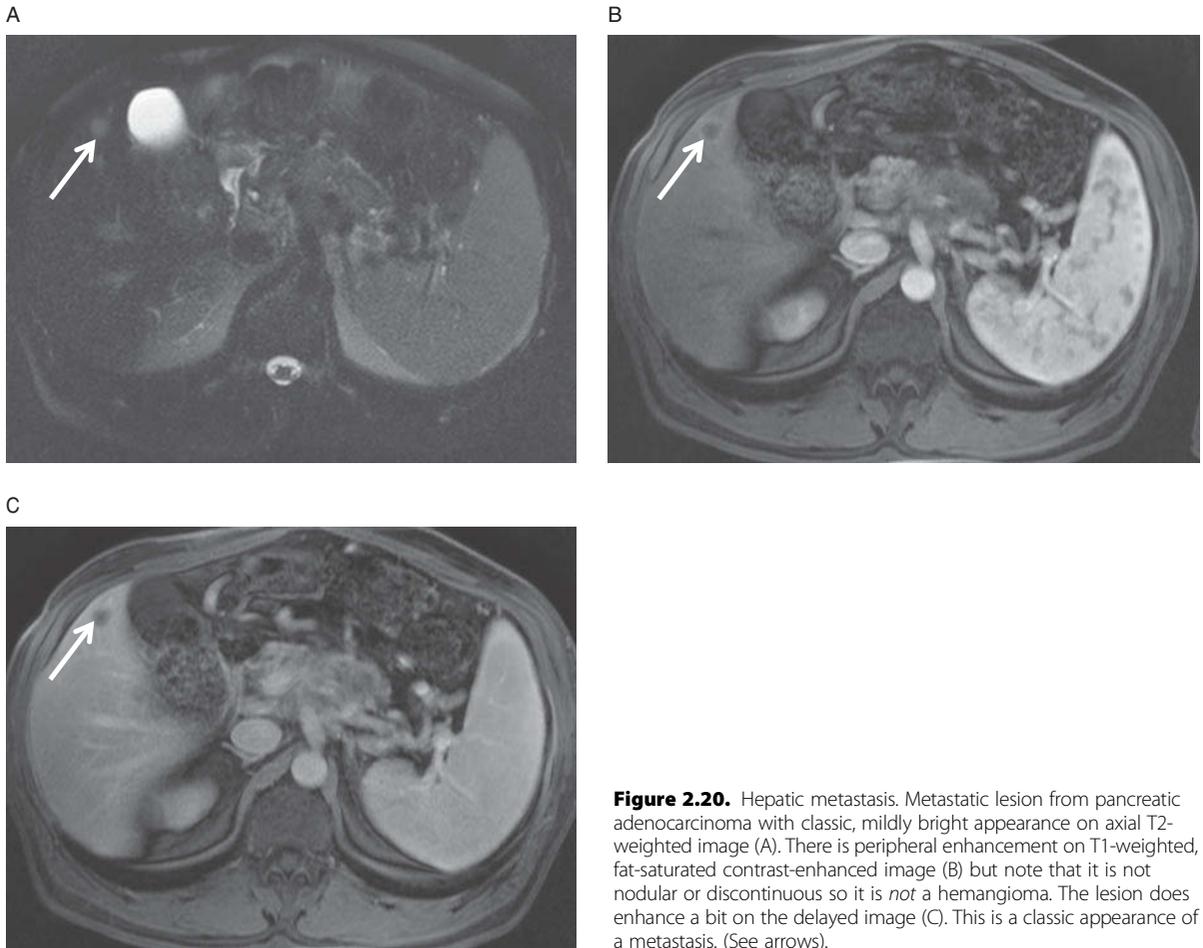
Hepatic metastasis. Metastatic lesion from pancreatic adenocarcinoma with classic, mildly bright appearance on axial T2-weighted image (A). There is peripheral enhancement on T1-weighted, fat-saturated contrast-enhanced image (B) but note that it is not nodular or discontinuous so it is *not* a hemangioma. The lesion does enhance a bit on the delayed image (C). This is a classic appearance of a metastasis. (See arrows).
